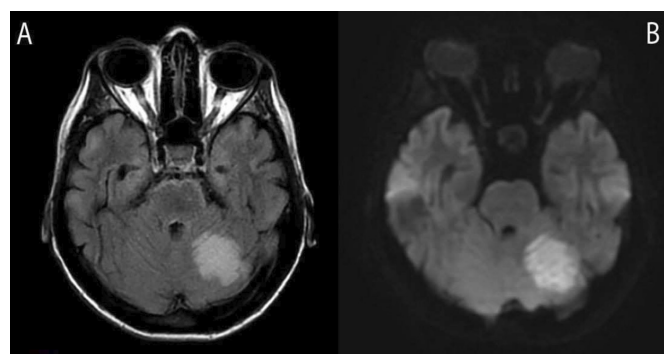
(A) Axial fluid-attenuated inversion recovery MRI demonstrating an ischaemic lesion in the left superior cerebellar artery territory. (B) Axial diffusion-weighted MRI revealing typical diffusion restriction in the same region.
